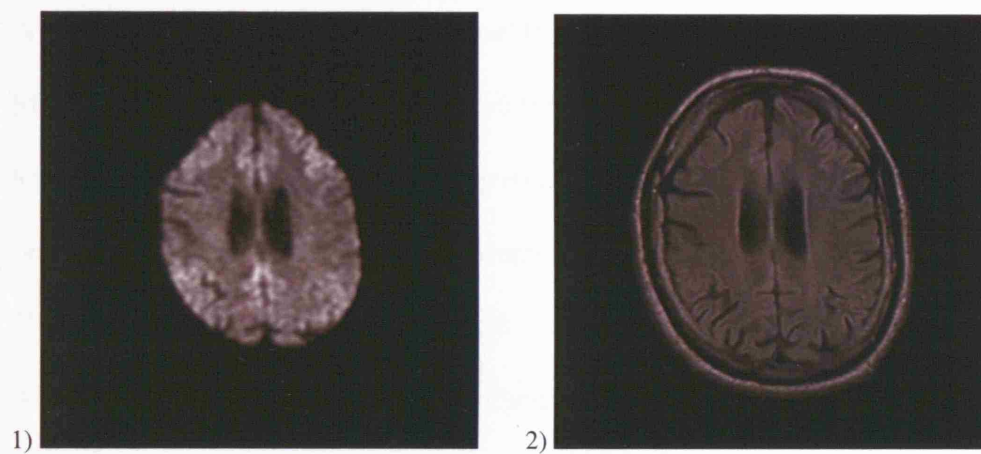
1) DWI and 2) FLAIR sequences in patient 17 with inherited prion disease
